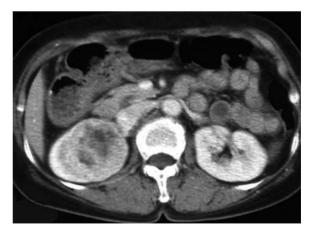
Collecting duct carcinoma in a 55-year-old woman. Axial contrast-enhanced CT scan shows a poorly marginated enhancing mass in the renal medulla of the right kidney.
